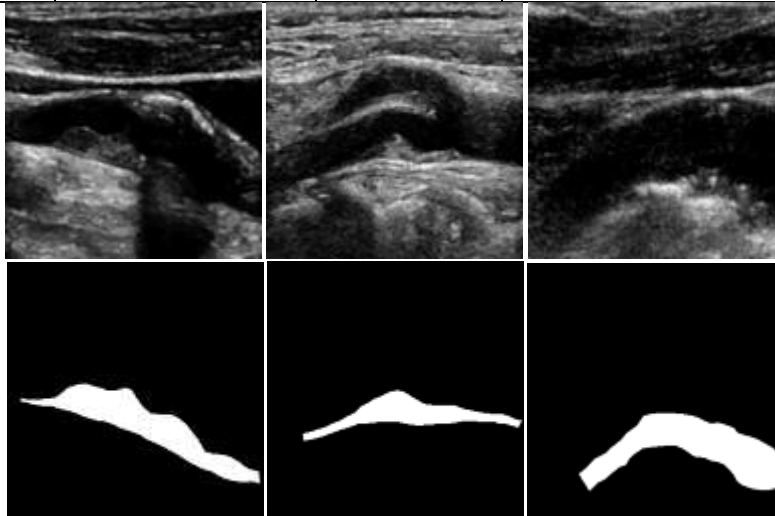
Vision Transformer based segmentation of ICA ultrasound images.
